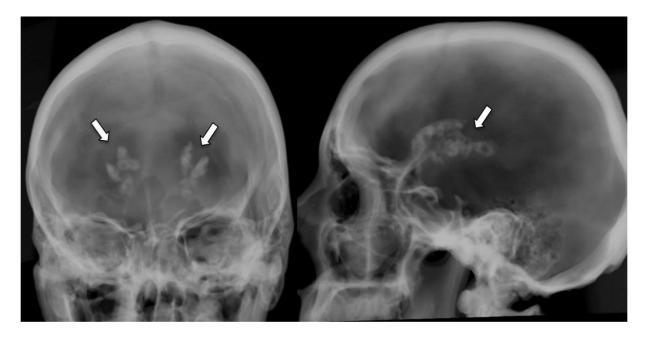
Anteroposterior and lateral thin multiplanar reconstruction CT views (mimicking skull radiographs) demonstrating deep intracranial calcifications (white arrows), in the area of the basal ganglia and thalamus. Those images demonstrate that such calcifications could be seen fortuitously on skull radiographs.
